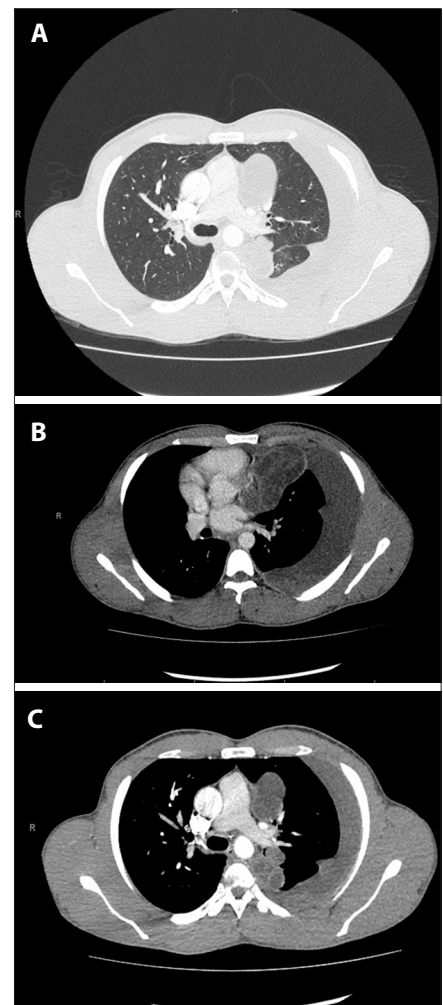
Computed tomography scans of the chest in lung window (A) and soft-tissue window (B and C). The scans confirm the large left pleural effusion with multiple thin-walled multilocular cysts containing daughter cysts. The cysts invade the mediastinum and abut the pulmonary artery and descending thoracic aorta.
